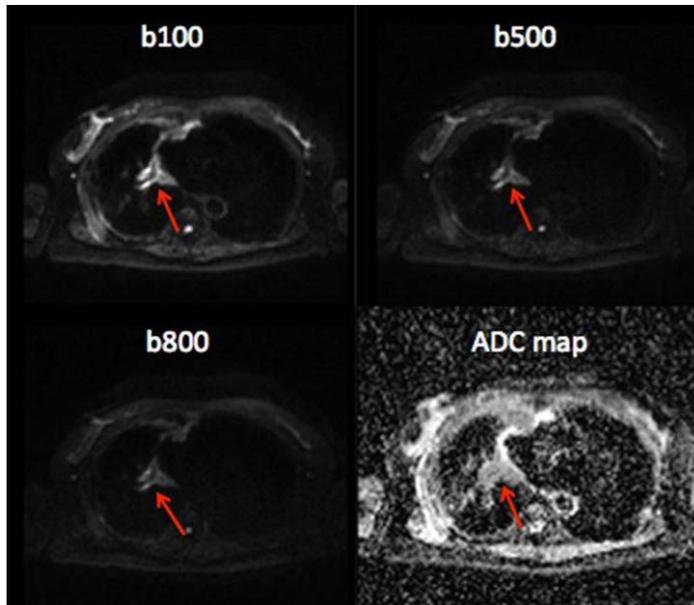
typical high quality DW-MRI images values and ADC map, which can now be achieved in a patient with malignant pleural mesothelioma.
